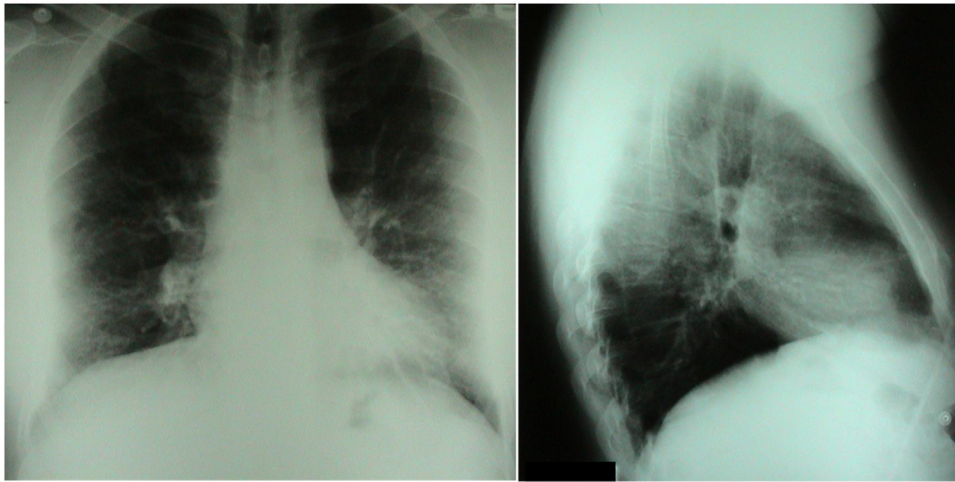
Chest X-ray (AP and Lateral): Lungs are clear. Both costo-phrenic angles are free.
